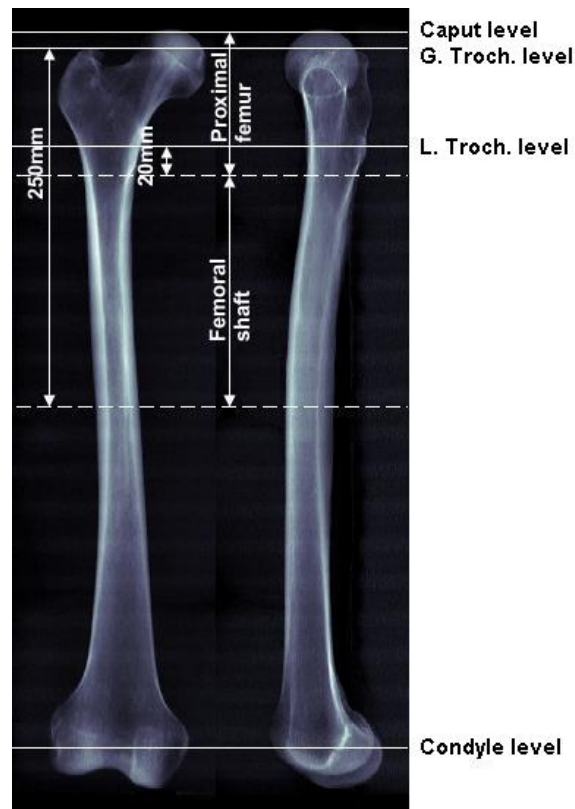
Medio-lateral and antero-posterior views of a femur reconstructed from projections of the CT images. The levels of proximal caput, greater trochanter (G.Troch.), lesser trochanter (L.Troch.) and the condyles (solid lines) are picked manually. The levels defining the femoral shaft (slashed lines) are at a fixed distance from trochanter major and minor for all femurs.
